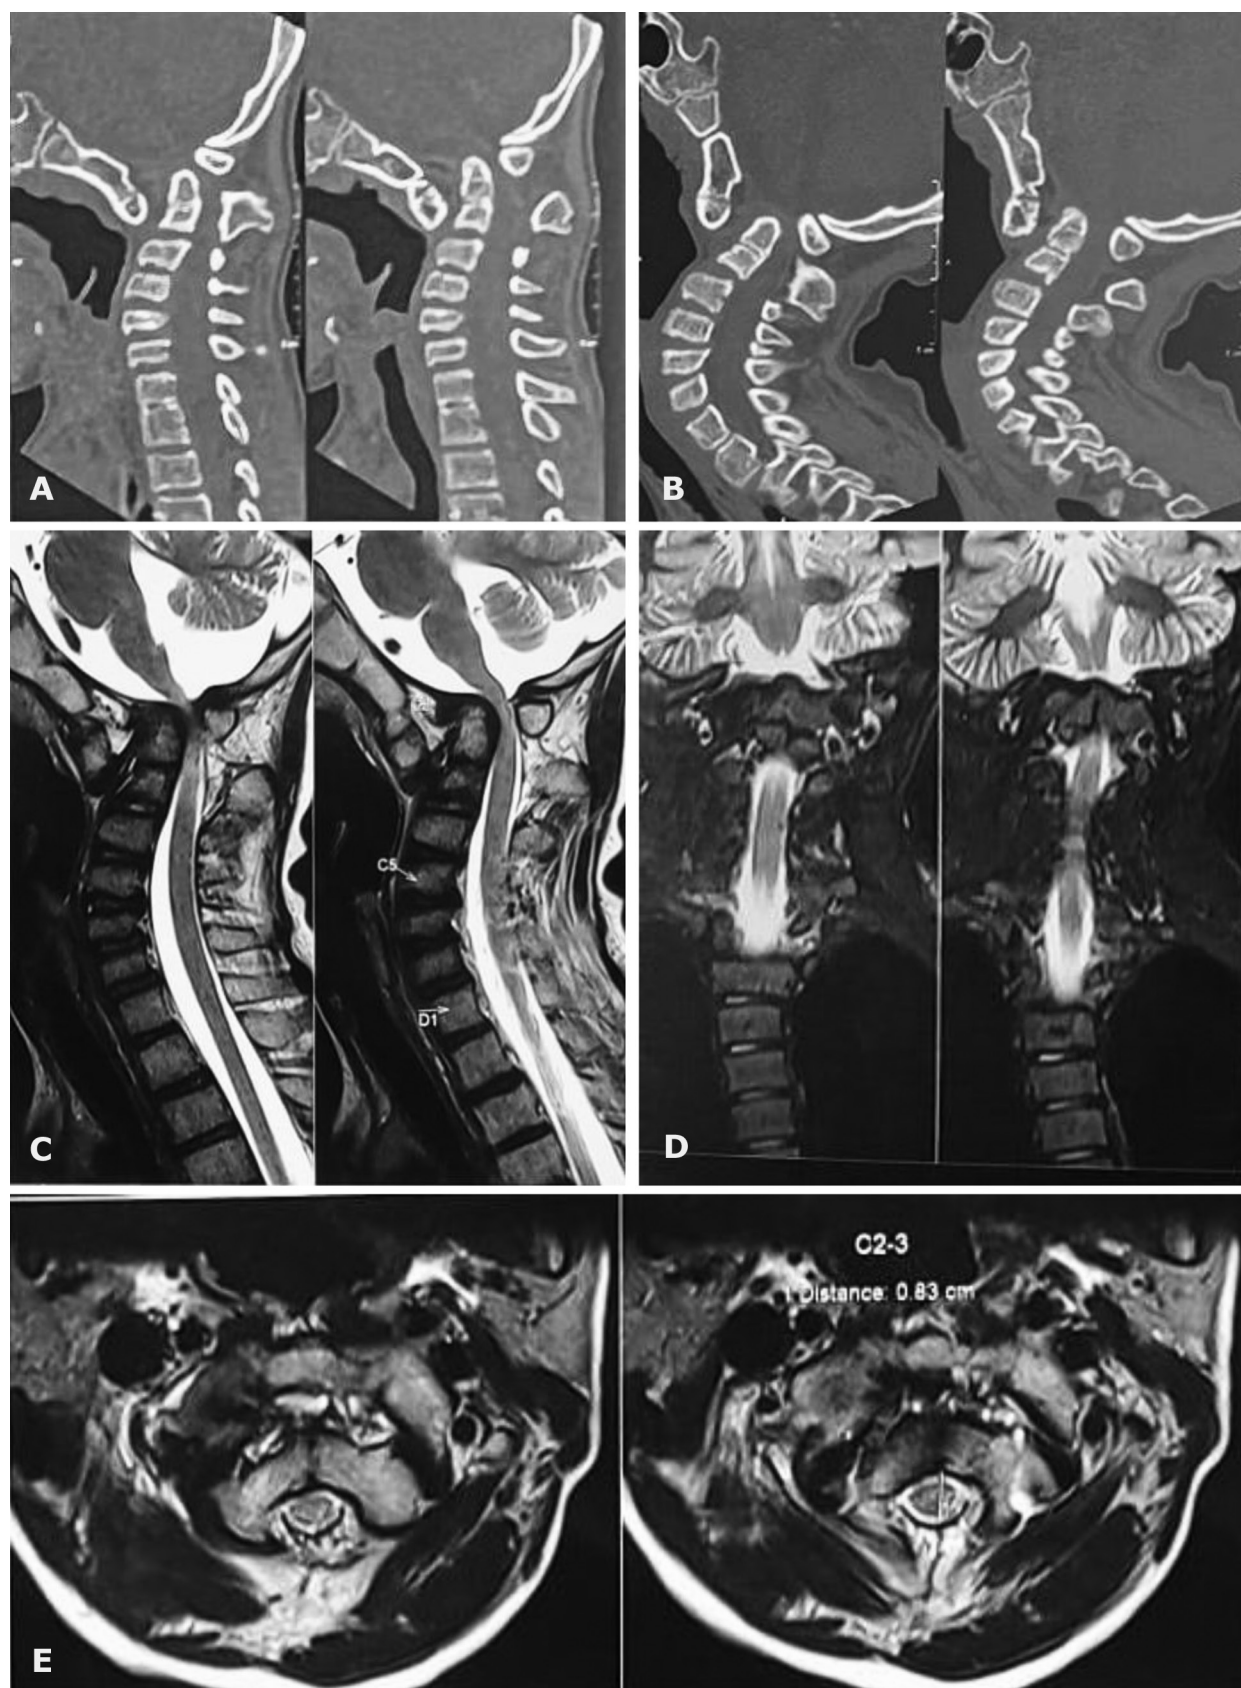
Preoperative non-contrast computed tomography (CT) of craniovertebral junction (CVJ).
